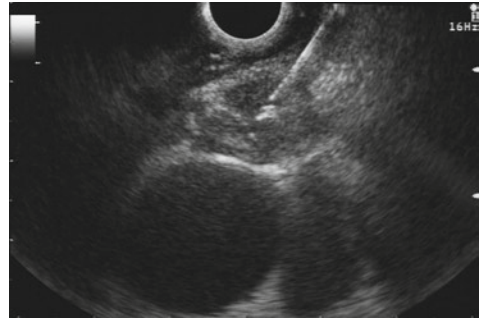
Esophageal ultrasound-guided fine needle aspiration biopsy of a perigastric node in a patient with left-sided malignant pleural mesothelioma
